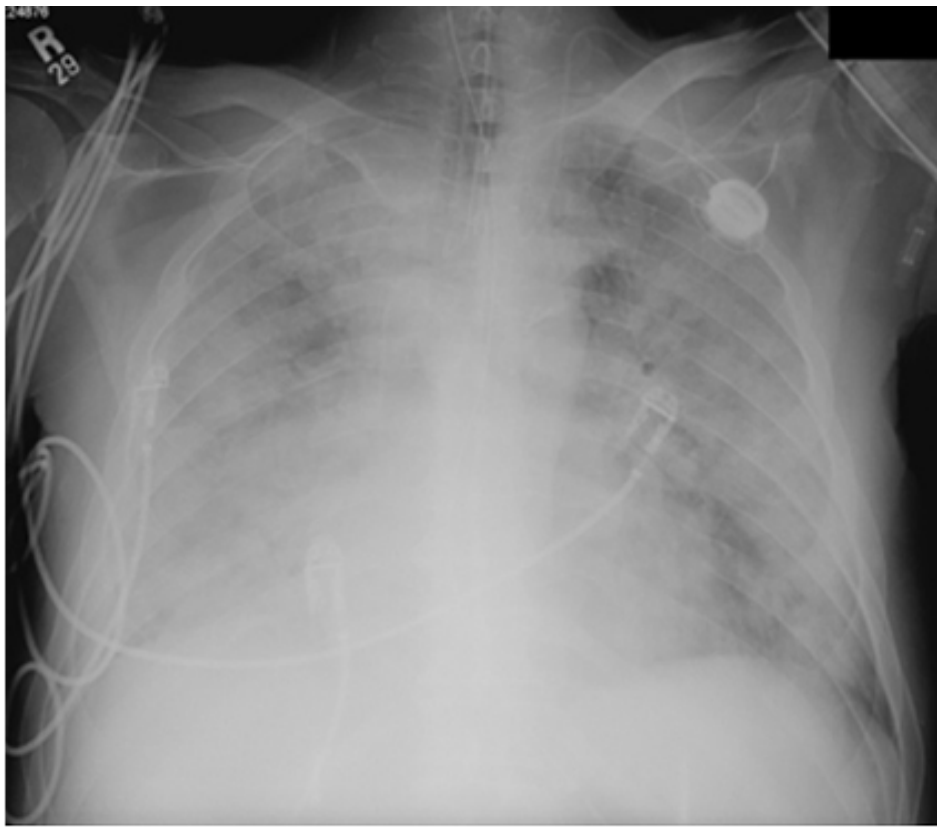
Chest X-ray on admission showing bilateral lower lobe patchy consolidations.
